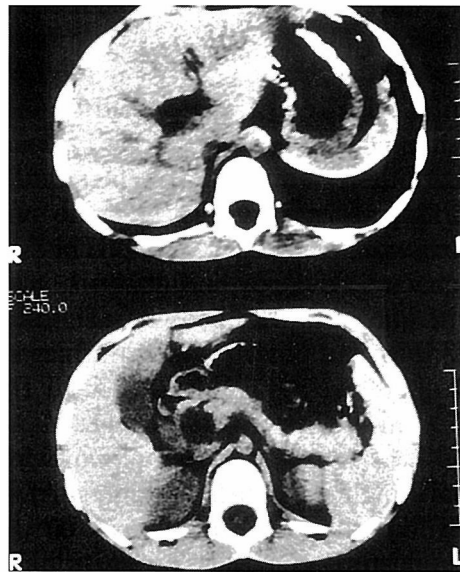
Abdominal CT scan showing dilatation of the intra- and extra-hepatic bile ducts
